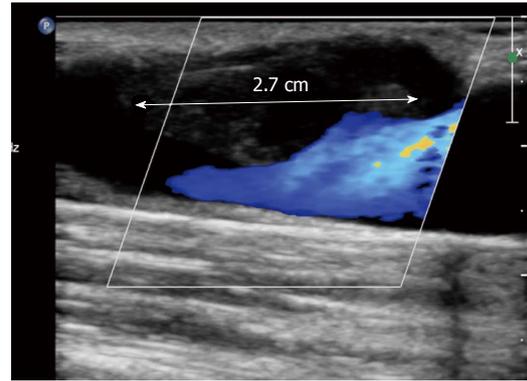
Colour Doppler scan showing a 2.7 cm long thrombus (white arrow) partially occluding the lumen of the arteriovenous fistula.
